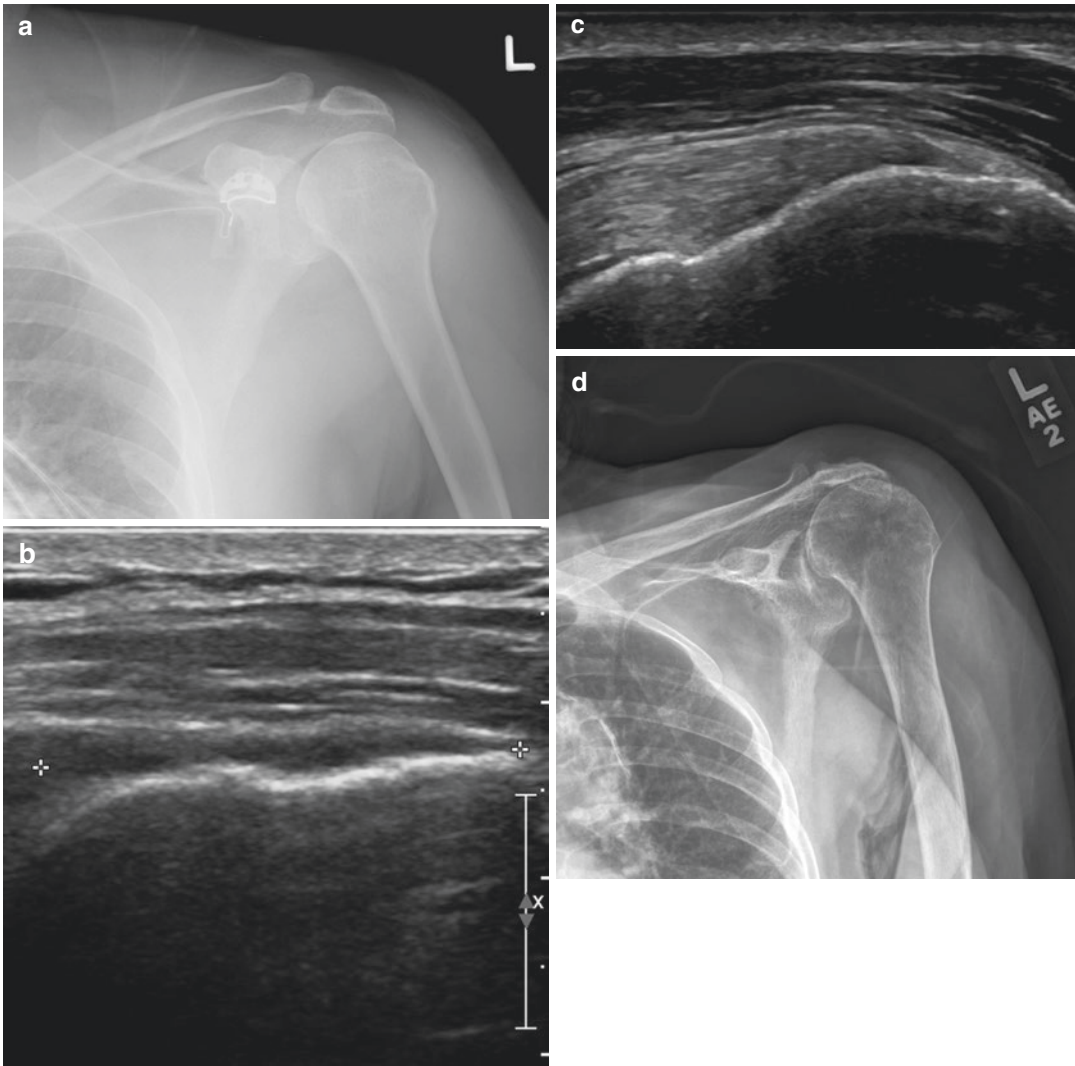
A 46-year-old man who presented with left shoulder pain and decreased range of motion after a motor vehicle accident. (a) Frontal radiograph of the left shoulder shows no significant abnormality. The humerus is in an internally rotated position. (b) Longitudinal US image of the supraspinatus shows a complete tear of the supraspinatus tendon, with a tendon gap at its attachment to the greater tuberosity (as indicated by the cross-hairs). This finding was not apparent on the radiographs.
